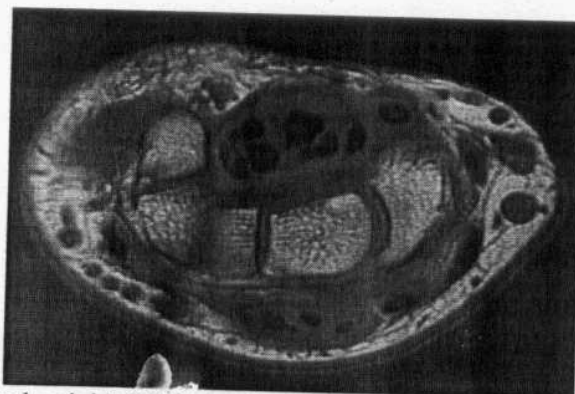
T2-weighted axial MRI at the level of the carpal bones show extensor carpi radialis longus tendon, extensor carpi radialis brevis tendon, extensor pollicis longus tendon, extensor carpi ulnaris tendon & extensor tendons to digits 2-5 (Quoted from Nadja Saupe, et al.,2005).
